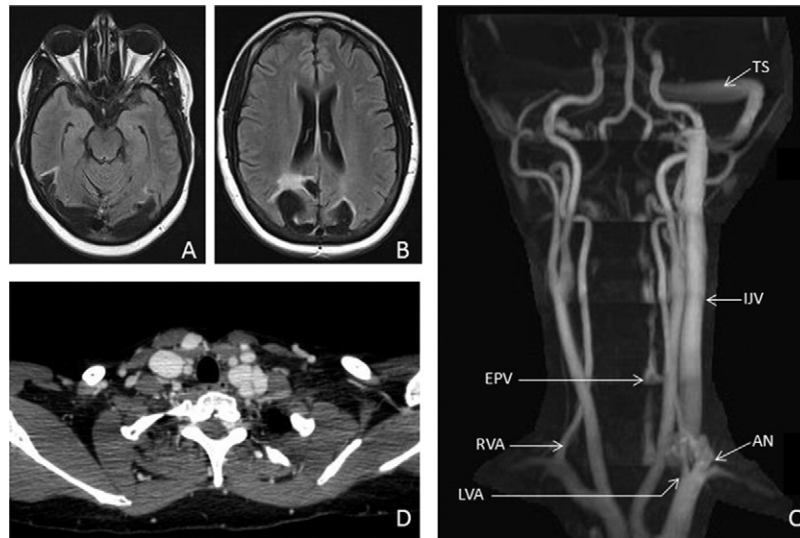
A, B, Magnetic resonance imaging (MRI) of the brain. Axial fluid attenuated inversion recovery (FLAIR) images demonstrate encephalomalacia resulting from old infarcts within bilateral paramedian parietal and occipital lobes and superior cerebellum. C, Magnetic resonance angiography (MRA). Time-of-flight technique demonstrates abnormal high signal within the left internal jugular vein (IJV), sigmoid and transverse sinuses (TS), and cervical epidural plexus venous (EPV) as a result of retrograde arterialized flow. A large aneurysm (AN) is present at the level of the left vertebral artery origin (LVA). Right vertebral artery (RVA) is normal. D, Computed tomography (CT) with contrast at the level of the clavicles demonstrates a large lobulated aneurysm anterior to the subclavian artery and prominent bilateral veins.
